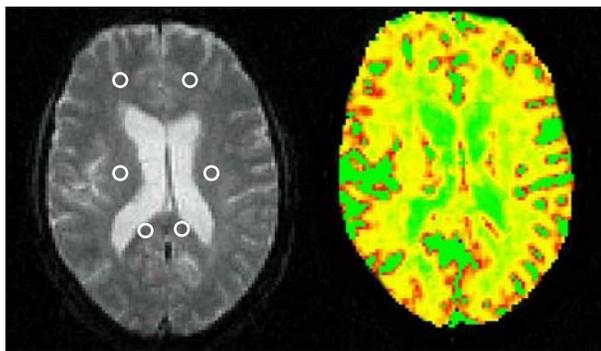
Left: Axial gradient-echo echo-planar MR image from a patient with PP-MS. Circular regions of interests are placed in the frontal, periventricular NAWM and in the splenium of corpus callosum bilaterally. Each ROI has an in-plane resolution of 2 pixels and was placed after visual co-registration with the transverse T2-weighted image to ensure that lesions were not included in the ROI. Right: Axial color-coded CBF map from the same patient.
